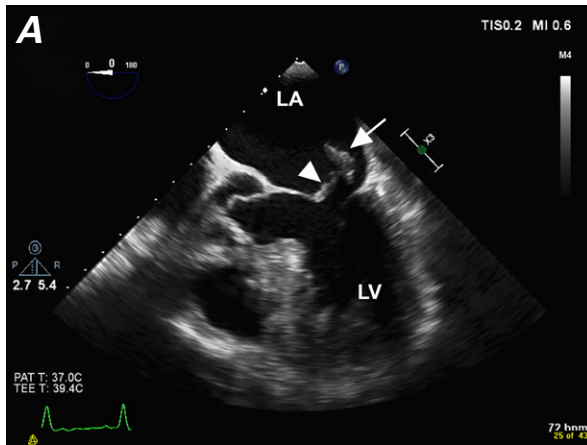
Transesophageal echocardiograms in mid-esophageal A) 4-chamber and B) long-axis systolic views show the ruptured papillary muscle fragment (arrow) and the A1 scallop (arrowhead) prolapsing into the left atrium (LA).
